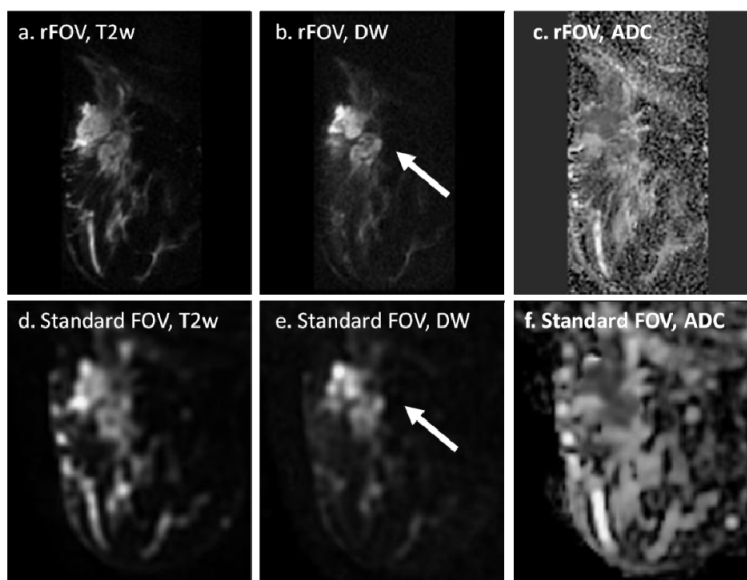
rFOV and standard FOV imaging data for a patient with invasive breast cancer. The tumor (arrow) appears more heterogeneous with rFOV DW-MRI. Both radiologists rated tumor depiction, heterogeneity, lesion conspicuity, and other qualitative features as superior on rFOV DW-MRI data as compared to standard. Quantitative analysis of the tumor ADC distribution showed that the minimum tumor ADC was lower with rFOV vs. standard FOV.
